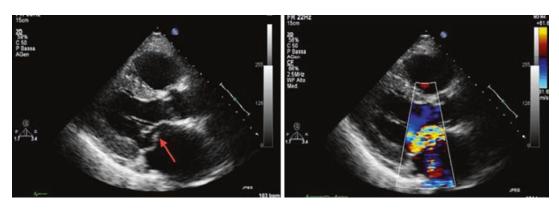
Posterior leaflet chordal rupture parasternal long axis view
